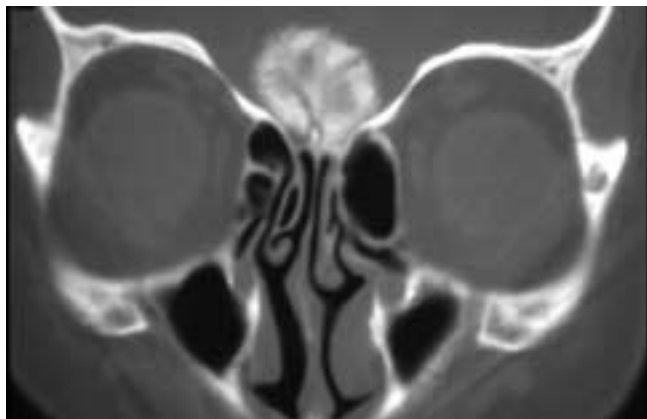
Coronal CT scan shows a heavily calcified ovoid mass in the anterior cranial fossa resting on the cribriform plate. This patient had an old “burnt-out” meningioma.
